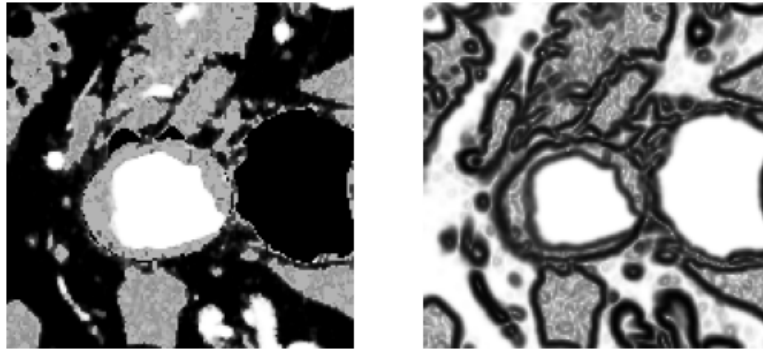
CTA and CTA's magnitude gradients. (Patient 2)
